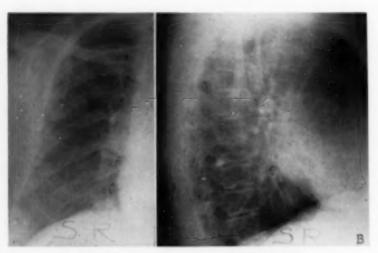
FIGURE 1A Figures 1A and 1B: Preoperative roentgenograms showing the "coin" lesion within the lower lobe of the right lung adjacent to and immediately posterior to the heart shadow.
